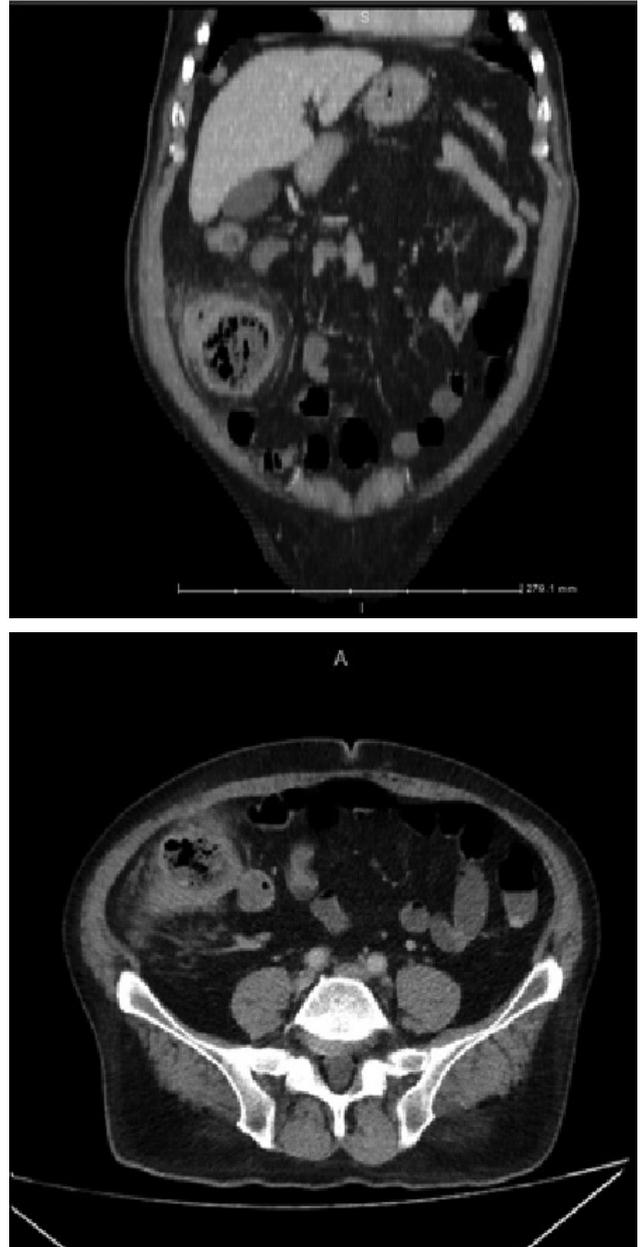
Abdominal CT scan image that shows thickened cecal wall, pericecal fluid, and heterogeneity.
